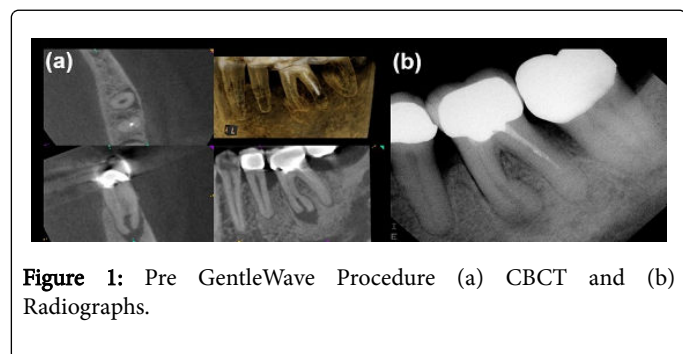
Pre GentleWave Procedure (a) CBCT and (b) Radiographs.
